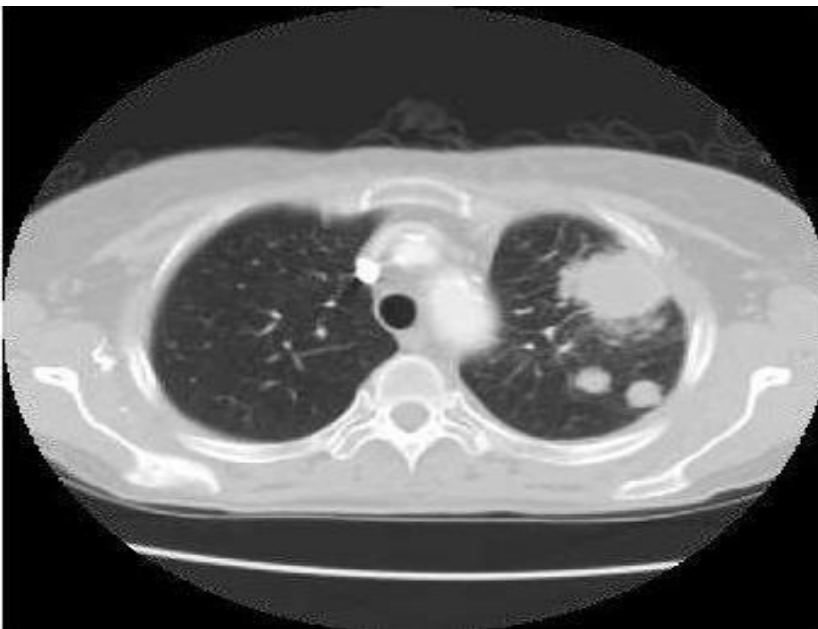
Manifestation of lung cancer on CT image showing nodules of about three centimetre (3cm) and above. Source of image (Widodo et al., 2020).
